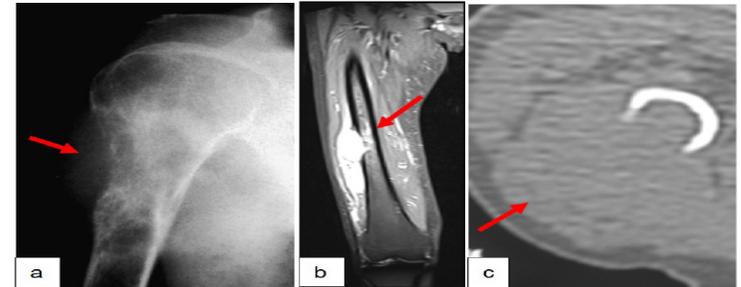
Plain film (a) shows a lytic lesion with aggressive radiological signs with ill defined margins and cortical destruction indicating soft tissue extension. MRI (b) depicts well the large soft tissue tumoral invasion and small medullary bone component. CT (c) shows the bone destruction but offers a limited view of the soft tissue component.
